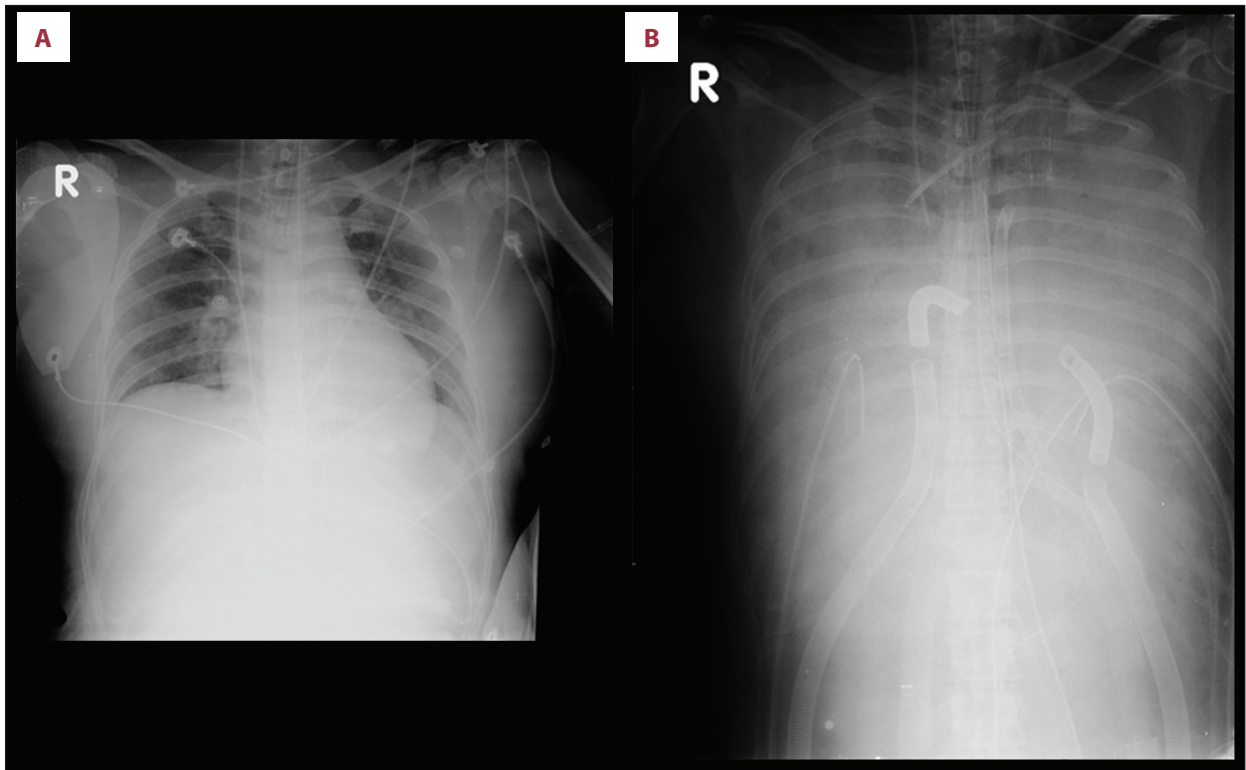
Chest radiography before (A) and after (B) bilateral ventricular assisted device. Bilateral diffuse consolidation B came from severe pulmonary hemorrhage.
